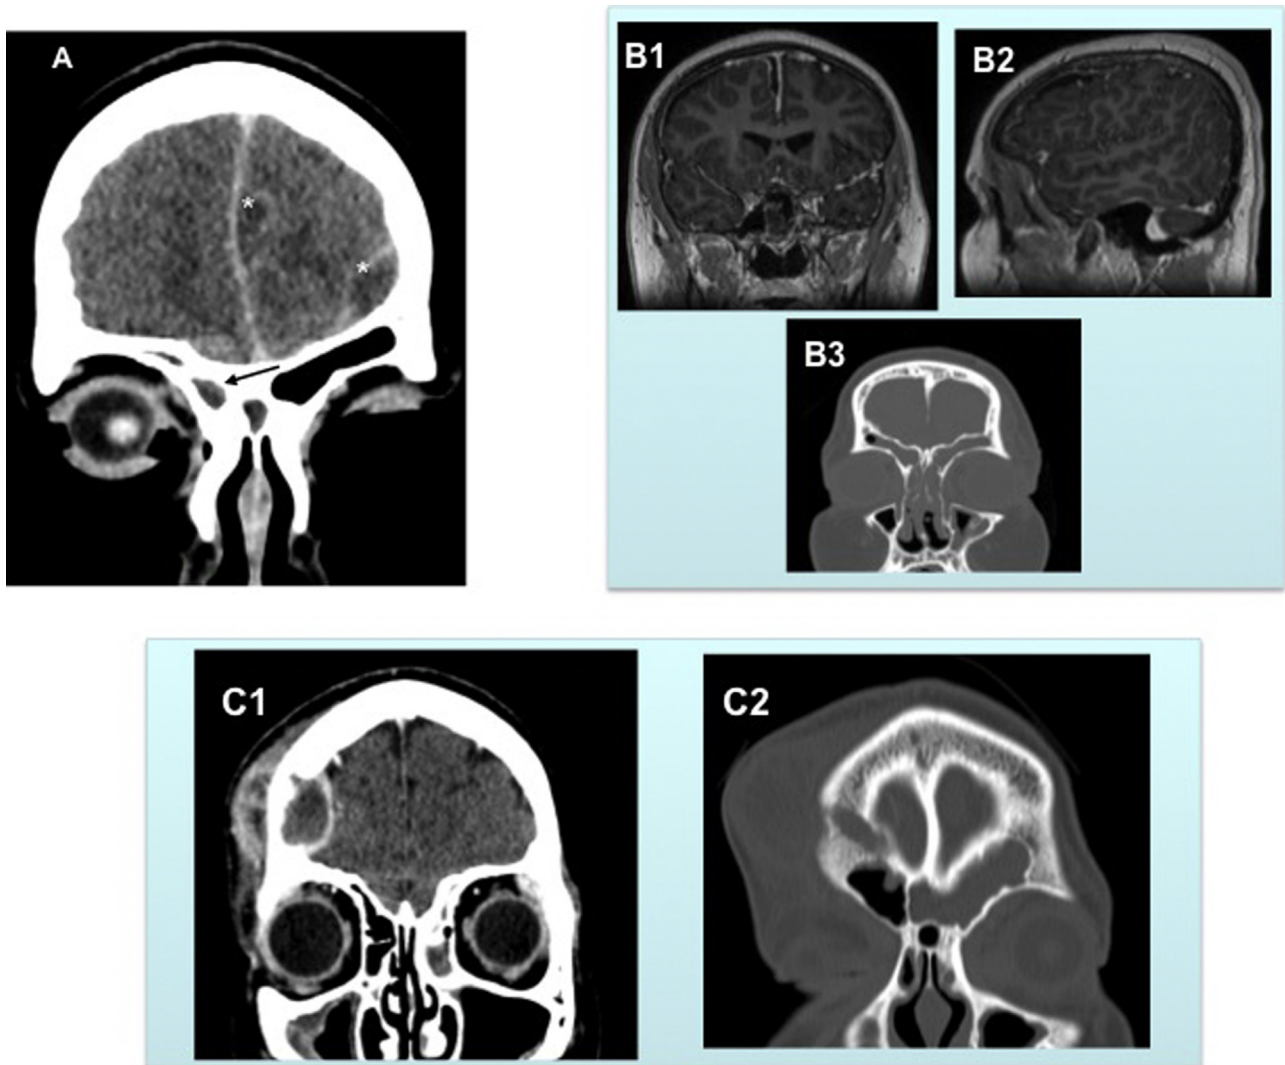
CT and MR imaging of empyema not in contact with the infected sinus. (A) In this patient, only the right frontal sinus was infected (black arrow) even though the SE was located on the opposite side (*). (B1–B3) SE with no visible continuity with the frontal or ethmoid sinuses. (C1–C2) Left frontal sinusitis and right frontal EE originated from Pott's puffy tumor.
